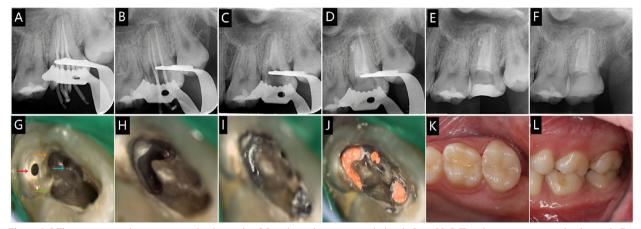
A-B The master apical cone periapical radiographs; C Distobuccal apex was sealed with iRoot BP; D The obturation periapical radiograph; E Four-month follow-up; F Nine-month follow-up; G Pulp cavity after preparation, red arrow for supernumerary tooth, orange for MB, bule for MB2, green for DB; H Pulp cavity after removing the interlayers of MB, DB and the supernumerary tooth; I iRoot BP in the distobuccal root canal (the white filling material); J Pulp cavity after root canal filling; K-L Onlay over tooth #27
